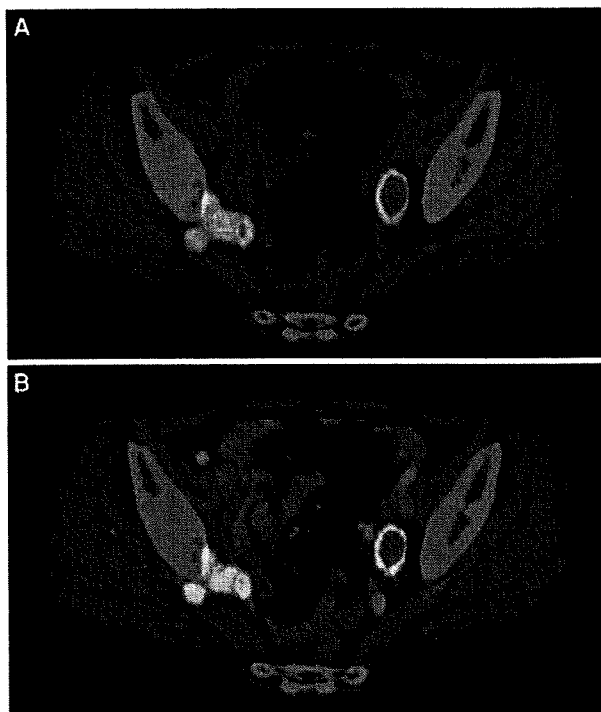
Axial noncontrast-enhanced PET/CT image (A) and contrast-enhanced PET/CT (B) shows enlarged nodes with increased uptake in patient with follicular lymphoma. Abnormal uptake is found in the right gluteal lesion. Disappearance of right upper gluteal artery, which reflects intravascular extension, is also seen on contrast-enhanced PET/CT. Intense uptake is observed in the left hydroureter.
